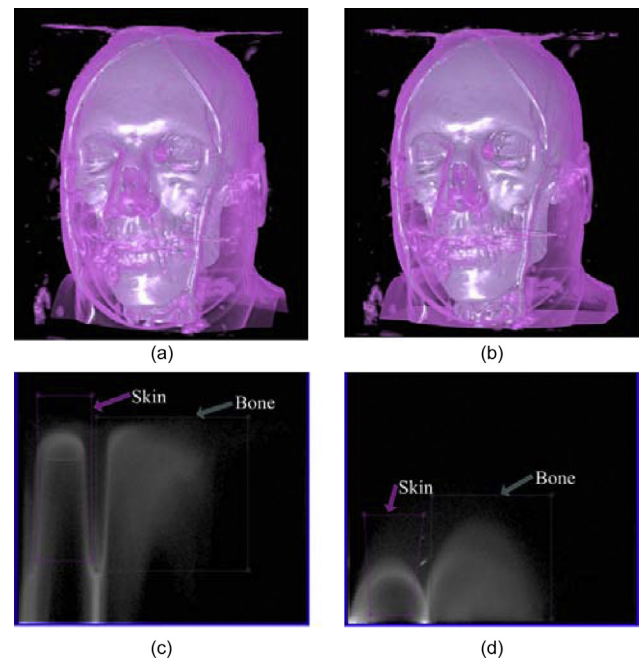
Comparison of the IS space (c) with the IGM space (d) on a CT head data. Their rendering results are shown in (a) and (b), respectively.
